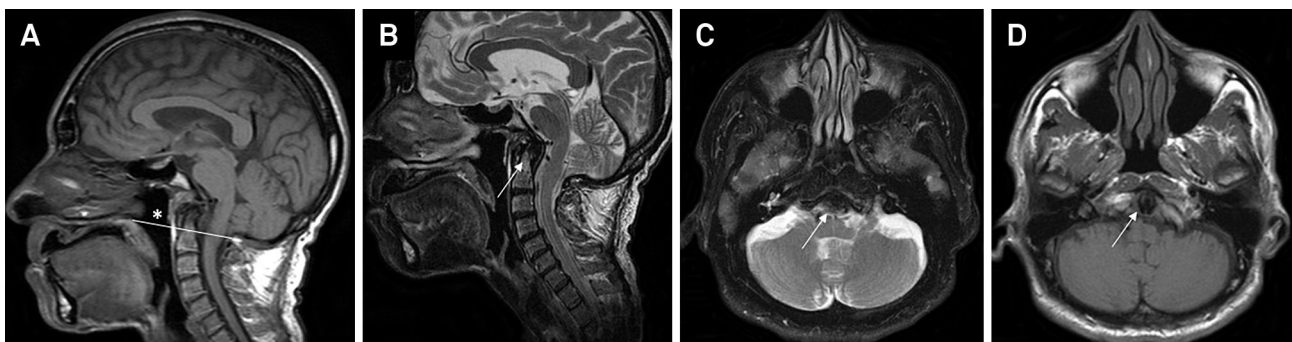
(A) T1-weighted and (B) T2-weighted midsagittal MR images showing important compression of the brainstem and medulla oblongata and a higher position of the tip of the odontoid process with a greater extension than 5 mm above the Chamberlain line (white asterisk, white line); (C) T2-weighted and (D) T1-weighted axial MR images unveiling ventral compression of medulla oblongata (odontoid process shown by white arrow).
